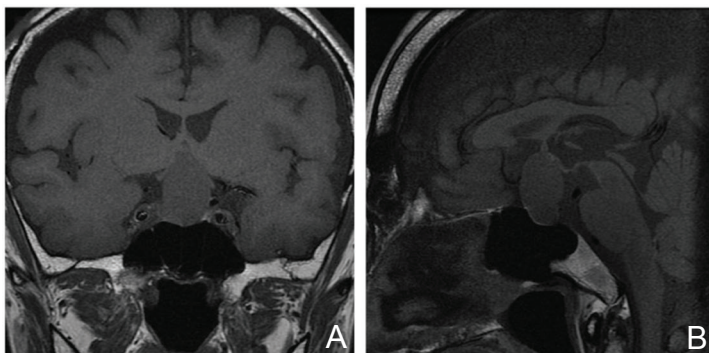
Case 2. Preoperative coronal (A) and sagittal (B) T₁-weighted magnetic resonance images show a homogenous cystic mass compressing the chiasm, suggestive of a Rathke's cleft cyst.
